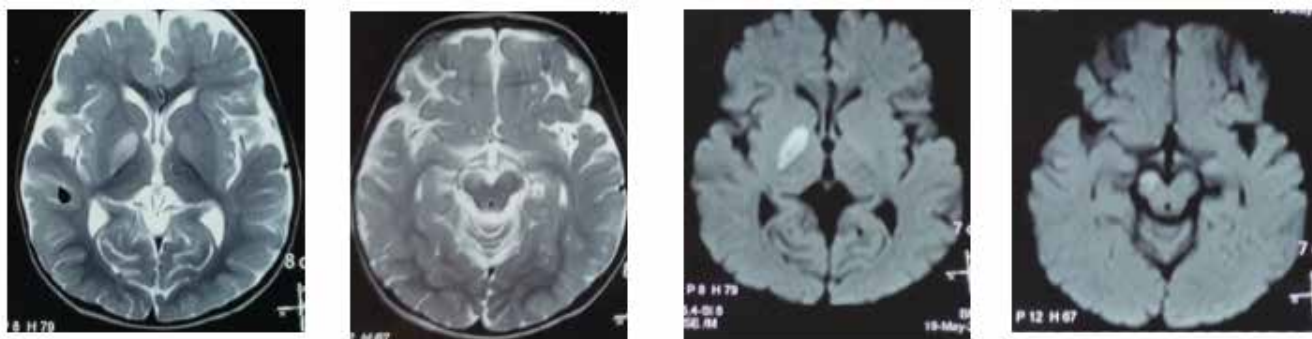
T2W & DWI Hyperintense Signals in Globus Pallidus and crus of Mid-Brain
